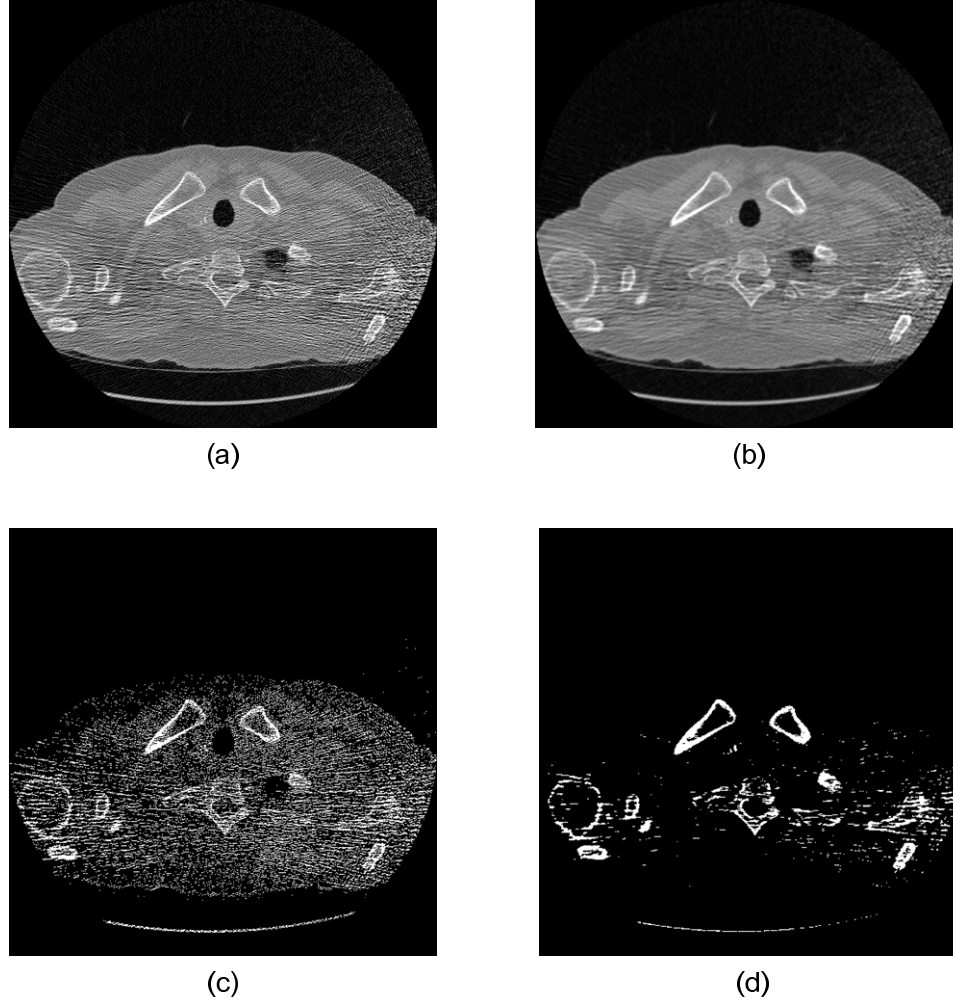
Effect of mean filter on thresholded output. An axial image is shown for: (a) raw CT image, (b) CT image after mean filtering, (c) raw image thresholded at 270 HU, (d) filtered image thresholded at 270 HU. Applying mean filter diminishes the effect of high-intensity noise, and bones are more distinguishable when thresholding.
